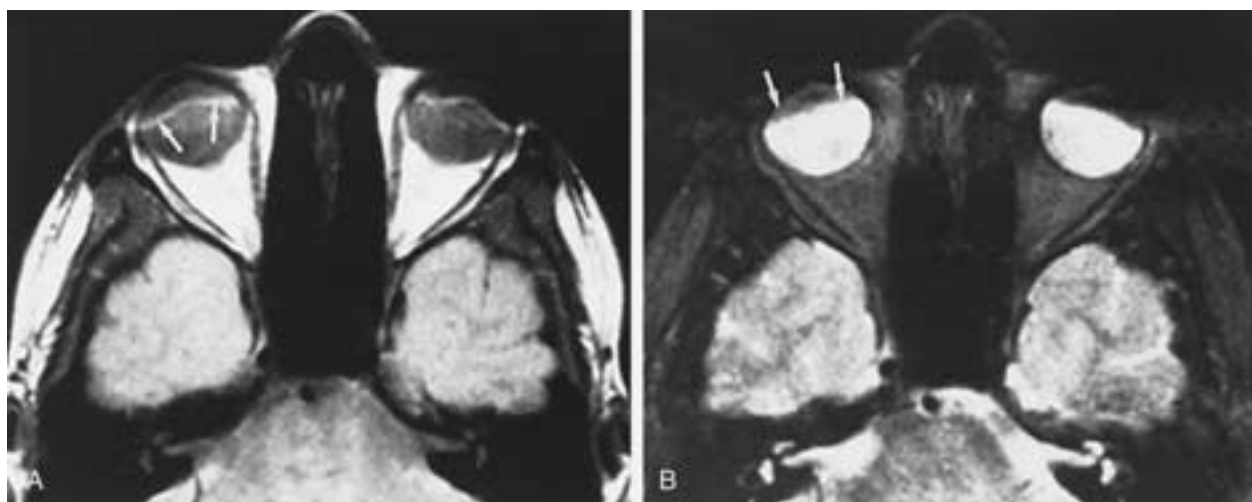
Axial PW (A) and T2-weighted (B) MR images show makeup artifacts (arrows).
